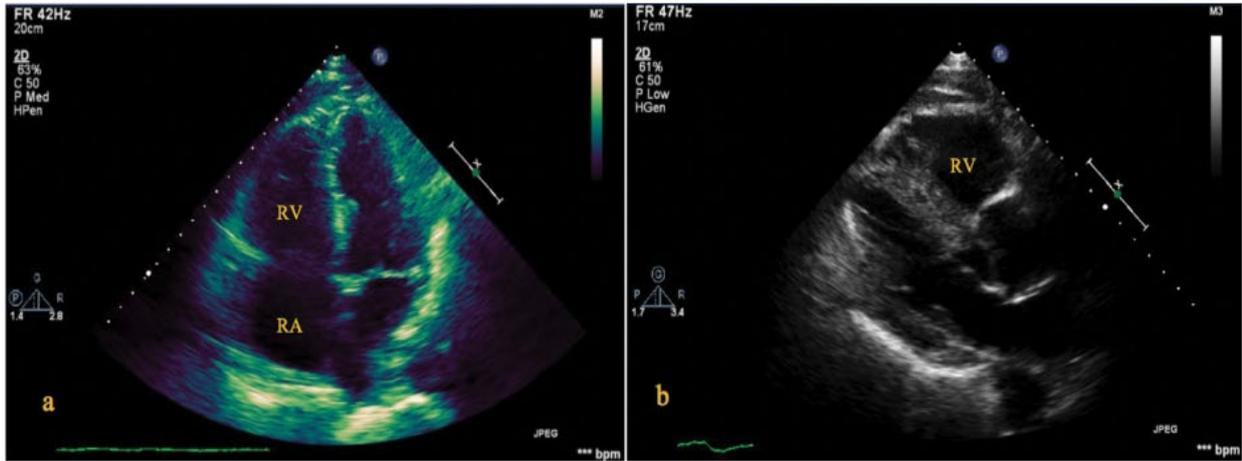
Echocardiogram showed an estimated ejection fraction of 55% with dilated inferior vena cava, (a) Right Atrium (RA), and (b) Right Ventricle (RV).
